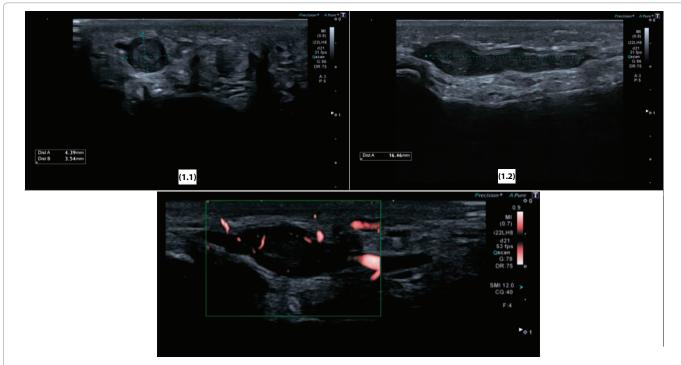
Ultrasound images showing a soft-tissue tumour of the ulnar proper digital nerve of the fourth digit just proximal to the PIP. Axial view (Figure 1.1) and longitudinal view (Figure 1.2) with duplex (Figure 1.3).
